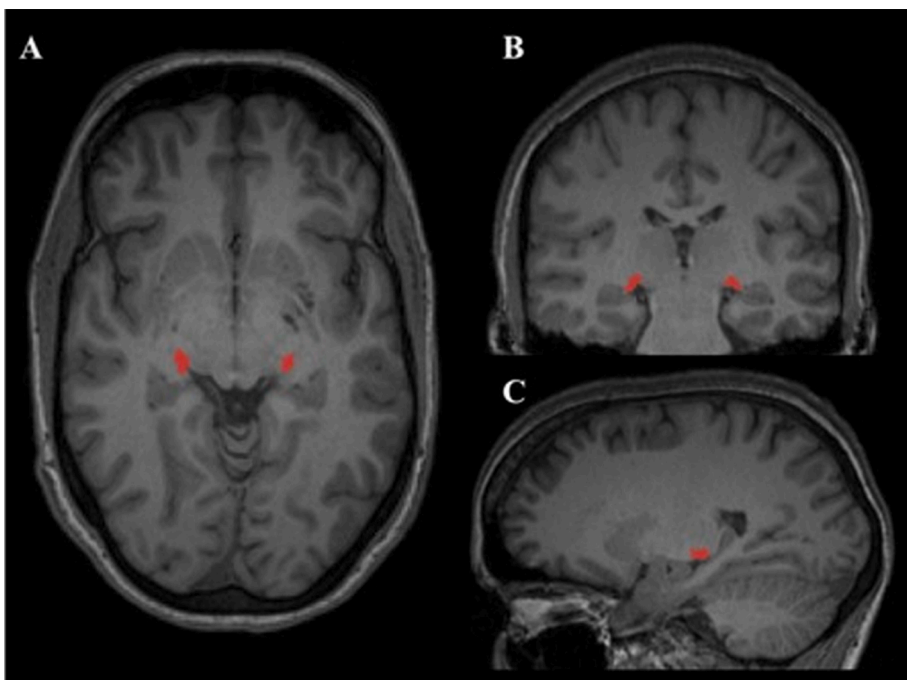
LGN segmentation by MAGeT. Legend: This figure is a representative lateral geniculate nucleus (LGN) segmentation in a control subject, as performed by the MAGeT brain algorithm (Chakravarty et al., 2013, 2006). The LGN is shown in red at: A) axial, B) coronal and C) sagittal view, on a 3D T1-weighted magnetization prepared rapid acquisition gradient echo (MPRAGE) sequence. (For interpretation of the references to colour in this figure legend, the reader is referred to the web version of this article.)
